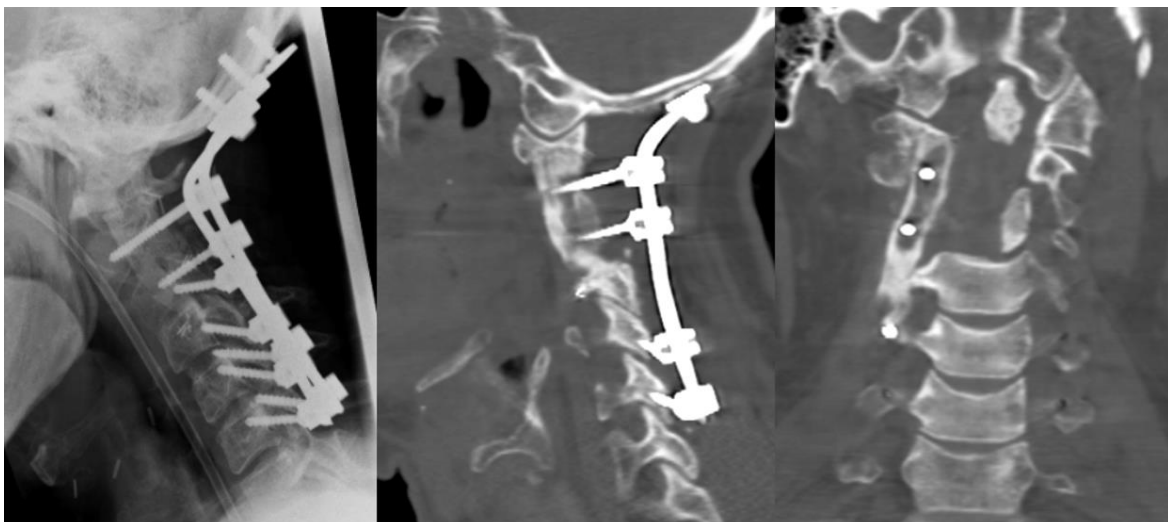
Postoperative radiograph and CT scan showing occipital cervical fusion and stabilisation of the fibula autograft with excision of the tumour
